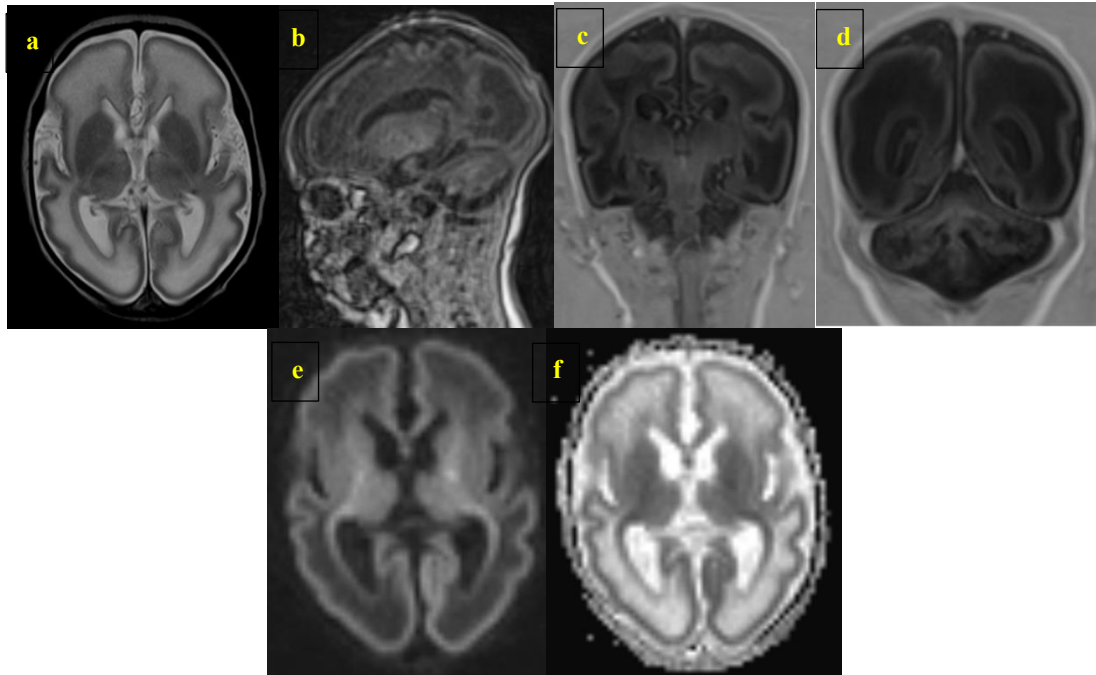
Brain MRI of the second case (T2 axial (a), 3D T1 sagittal (b) and TIR coronal (c, d), DWI (e, f)) revealed diffuse signal abnormalities of the periventricular white matter, appearing hyperintense on T2-weighted images (a) and hypointense on T1-weighted images (b), with no diffusion restriction (e, f).
